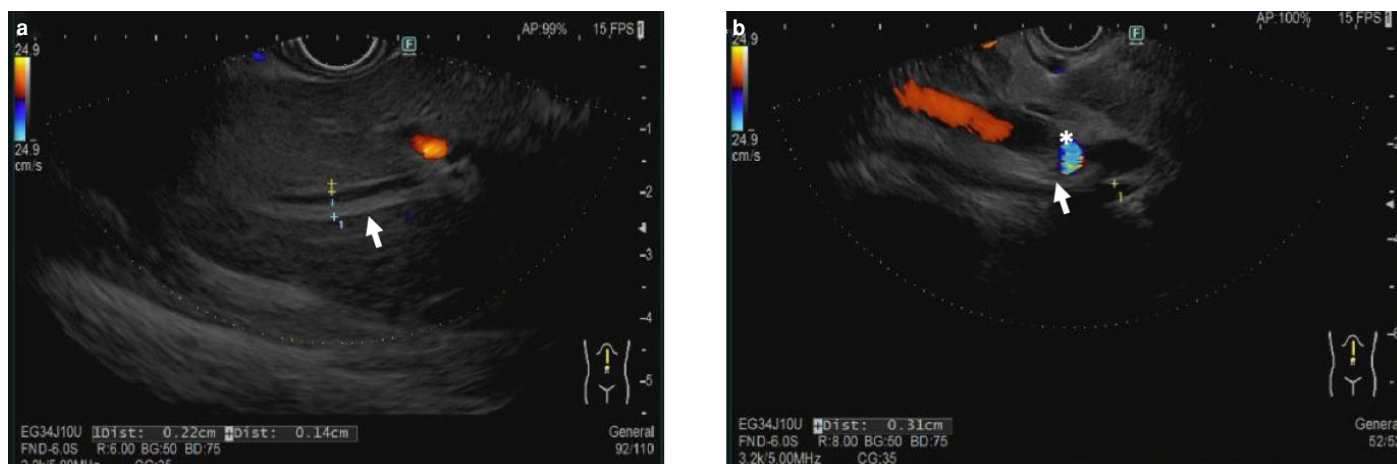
Linear endoscopic ultrasound shows thickening of the intrahepatic bile duct wall and periportal soft tissue. (a) Thickening of the intrahepatic bile duct wall (arrow). (b) Thickened whitish soft tissue (*) surrounding the left portal vein branch (arrow).
